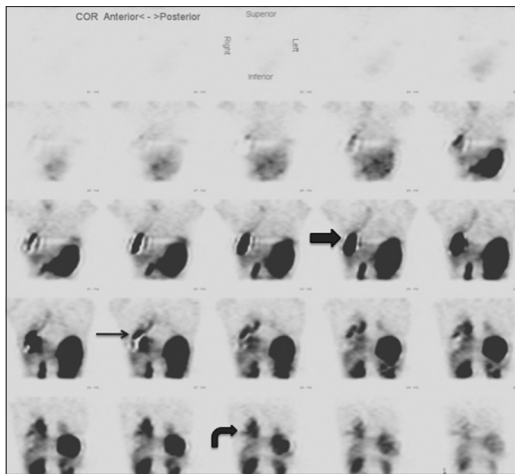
Coronal single-photon emission computed tomography images from the same cholescintigraphy study as in Figure 3, obtained following the 60-min planar images. There is an accumulation of the radiotracer in the hepatic dome abscess (thick arrow), in the fistulous tract (thin arrow) and in the right lower lobe consolidation (curved arrow). These images more accurately identify the location of the bronchobiliary fistula
